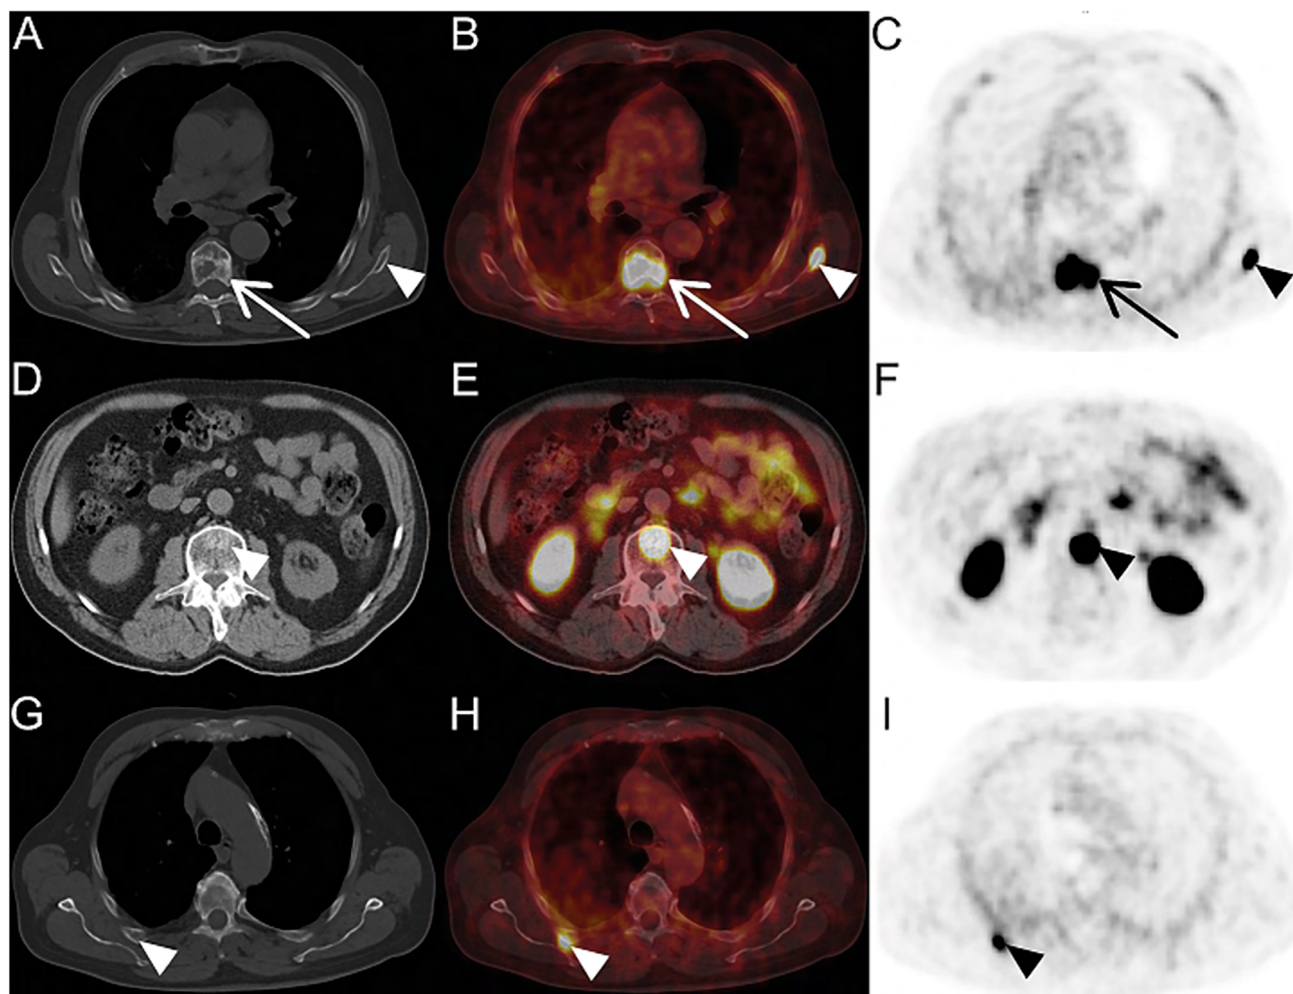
[^{68}Ga]Ga-PSMA-11 PET/CT images which show foci of increased marker accumulation in bones, mostly without visible change in CT examination; A — CT; B — fusion; C — PET — the arrow points to the lesion in Th7 vertebra, visible on the PET as well as on the CT as mixed bone metastasis, the arrowhead points at the foci in left scapula — bone metastases visible only in the PET/CT; D — CT; E — fusion; F — PET — the axial cross-section through L1 vertebra — the arrowhead points into the focus of increased tracer accumulation in PET with a hardly visible lesion in CT; G — CT; H — fusion; I — PET — the axial cross-section through left rib — the arrowhead points into the focus of increased tracer accumulation visible only in PET without visible lesion in CT
